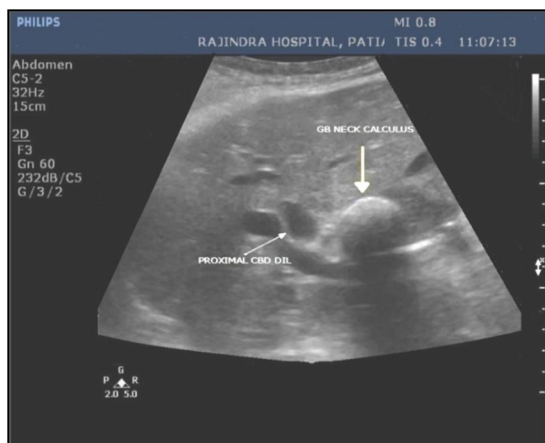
Ultrasonography abdomen showing an echogenic mass with distal acoustic shadow in the cystic duct region/neck of the gall bladder. Proximal dilatation of common bile duct present.
